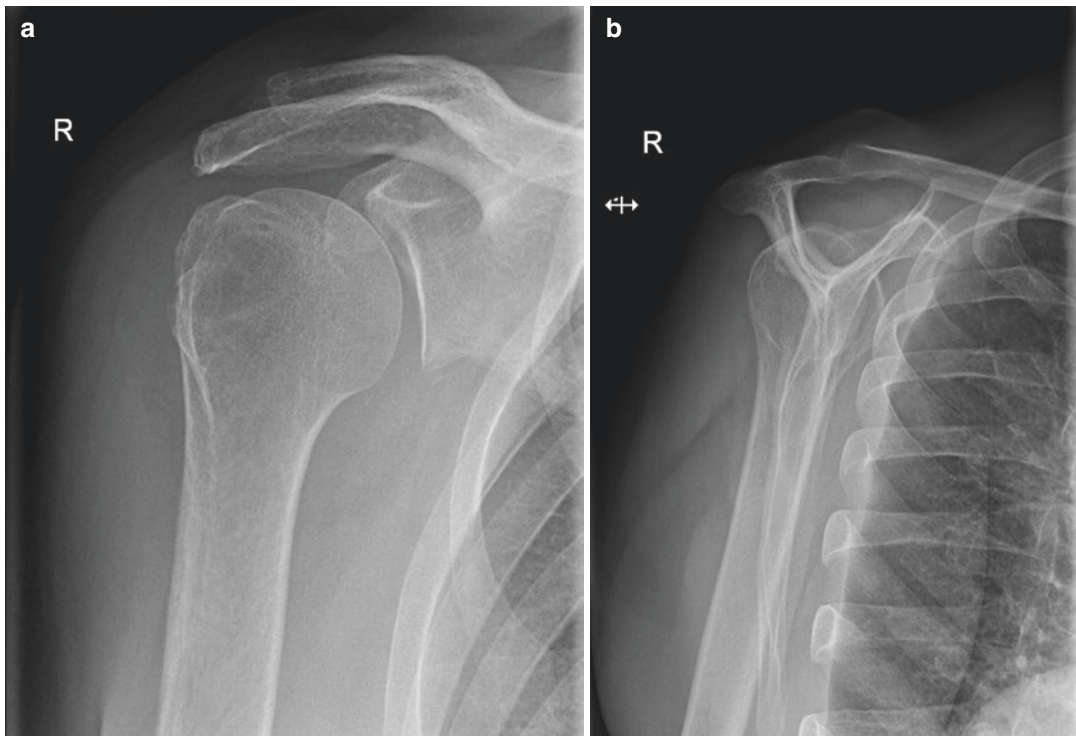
X-ray of the right shoulder with AP view (a) and Y view (b): A slight cranial translation of the humeral head without glenohumeral arthrosis is seen
